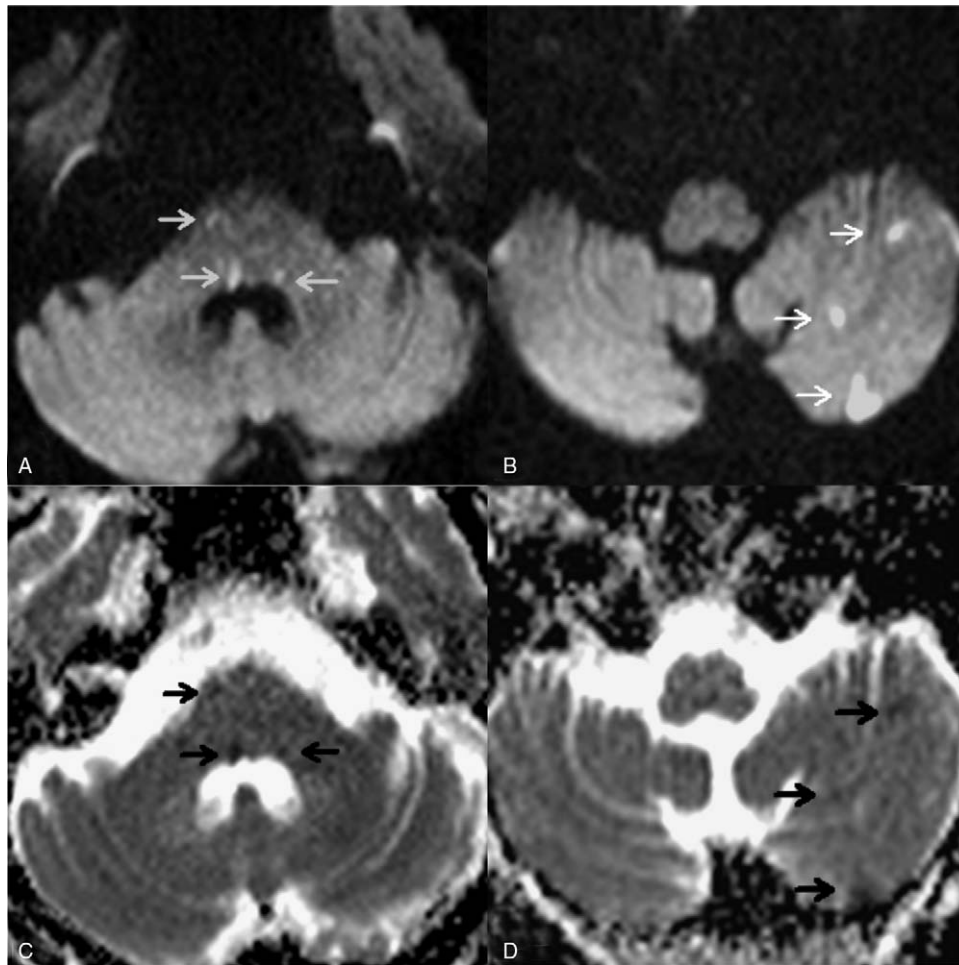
(A–D) Cranial MRI. Axial diffusion-weighted imaging (DWI) showed a high-intensity lesion comprising bilateral pontine tegmentum, basilar part of right paramedian pontine, and left cerebellar hemisphere (A and B, white arrows), with low apparent diffusion coefficient signals in corresponding regions, indicating an ischemic lesion (C and D, black arrows).
